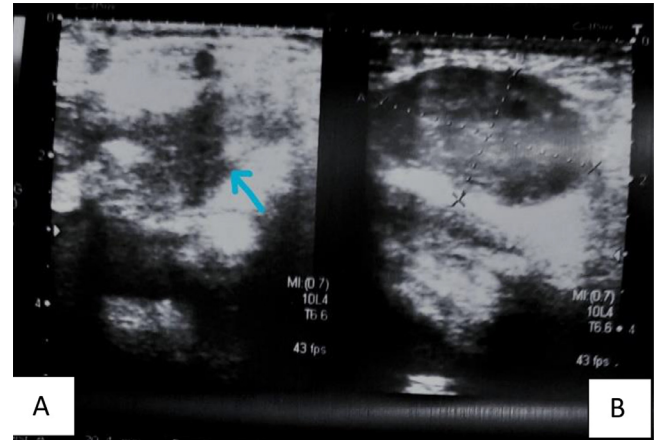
(A) Sonography of the right labium majus by linear probe demonstrates an ovoid shaped hypoechoic lesion containing few cysts inside suggest ovary which is measured 30 mm x 17 mm. (B) Color Doppler ultrasound shows no blood flow within the herniated ovary representing strangulation.
